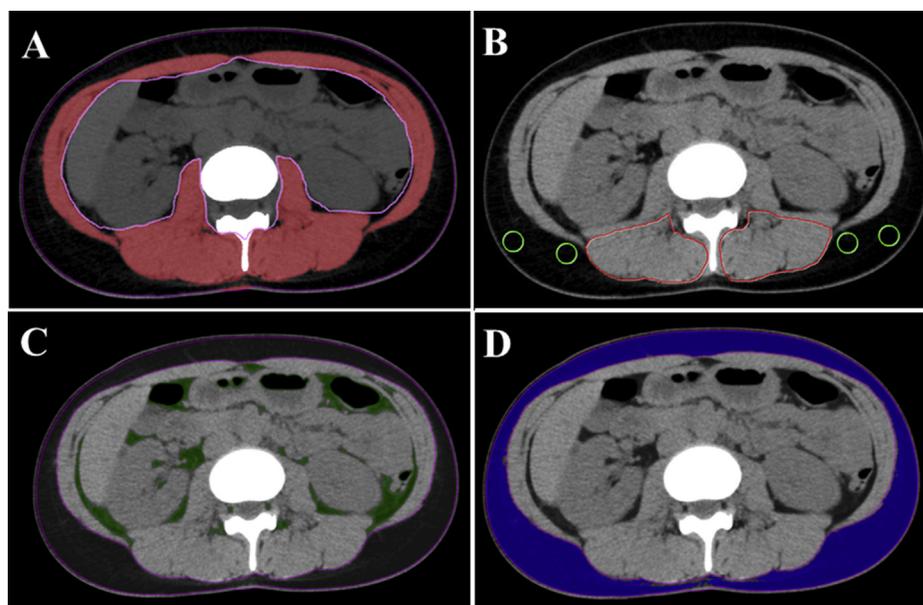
Cross-sectional CT images at the L3 level. Skeletal muscle areas are calculated as areas of -29 to 150 HU (A). IMAC is calculated by dividing the CT value of the multifidus muscle with that of subcutaneous fat (B). Visceral and subcutaneous adipose tissue areas are calculated as areas of -150 to -50 HU (C) and -190 to -30 HU (D), respectively. CT, computed tomography; HU, Hounsfield units; IMAC, intramuscular adipose tissue content.
